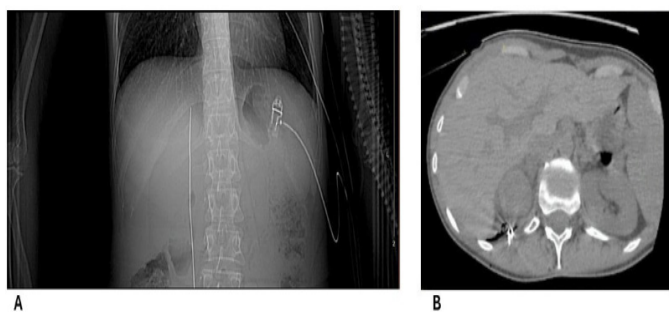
CT-guided percutaneous radiofrequency ablation of the right adrenal metastasis.
